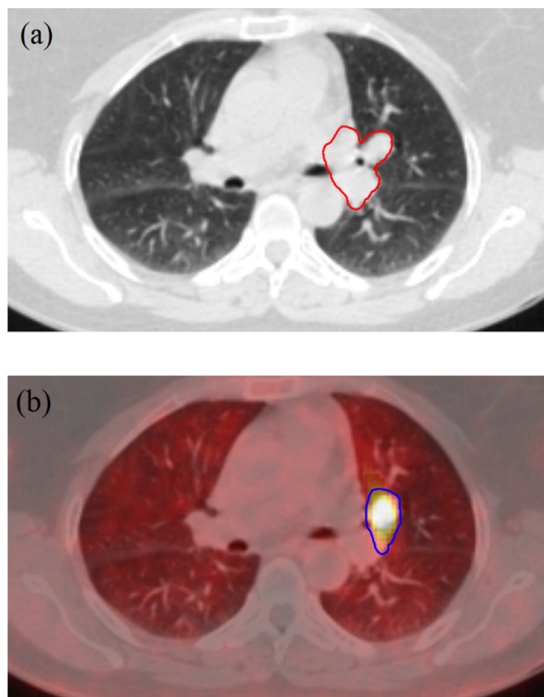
Tumor volume defined by: a) only CT image, b) PET/CT image.
